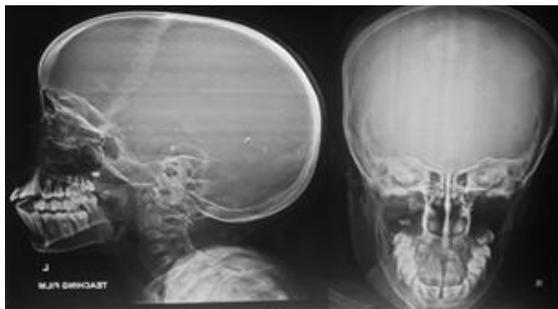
Skull X-ray lateral and antero-posterior view did not reveal much .Diploic space was preserved with grossly normal density of the skull bones. No evidence of basilar invagination.
